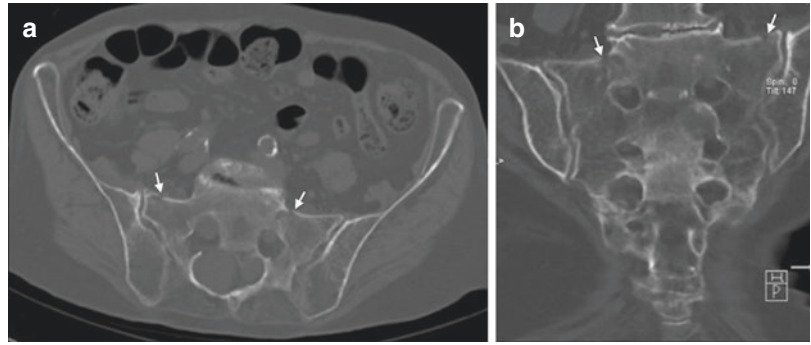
CT including (a, b) coronal and (c) sagittal views demonstrating bilateral vertical SIF with horizontal component at S2 (arrows)
